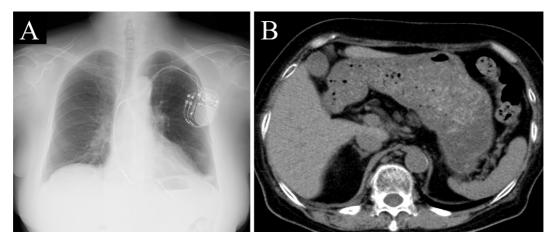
Chest X-ray (A) and computed tomography (B) findings acquired 17 days after initiating corticosteroid administration showing improvement in the atelectasis at the bilateral lower lobes and diffuse diaphragm thickening.
